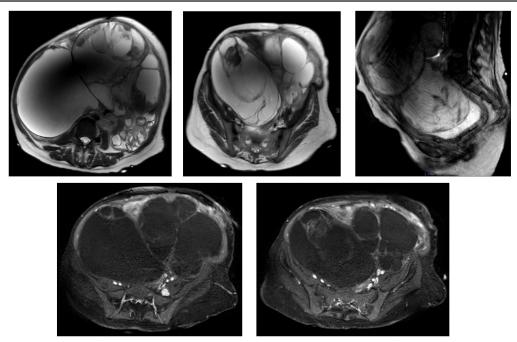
Abdominopelvic MRI showing two large mass of mixed ovarian origin, mostly fluid in Hypersignal T2 not enhanced after Gado injection with fleshy portions and peripheral nodules and thin internal septa.
